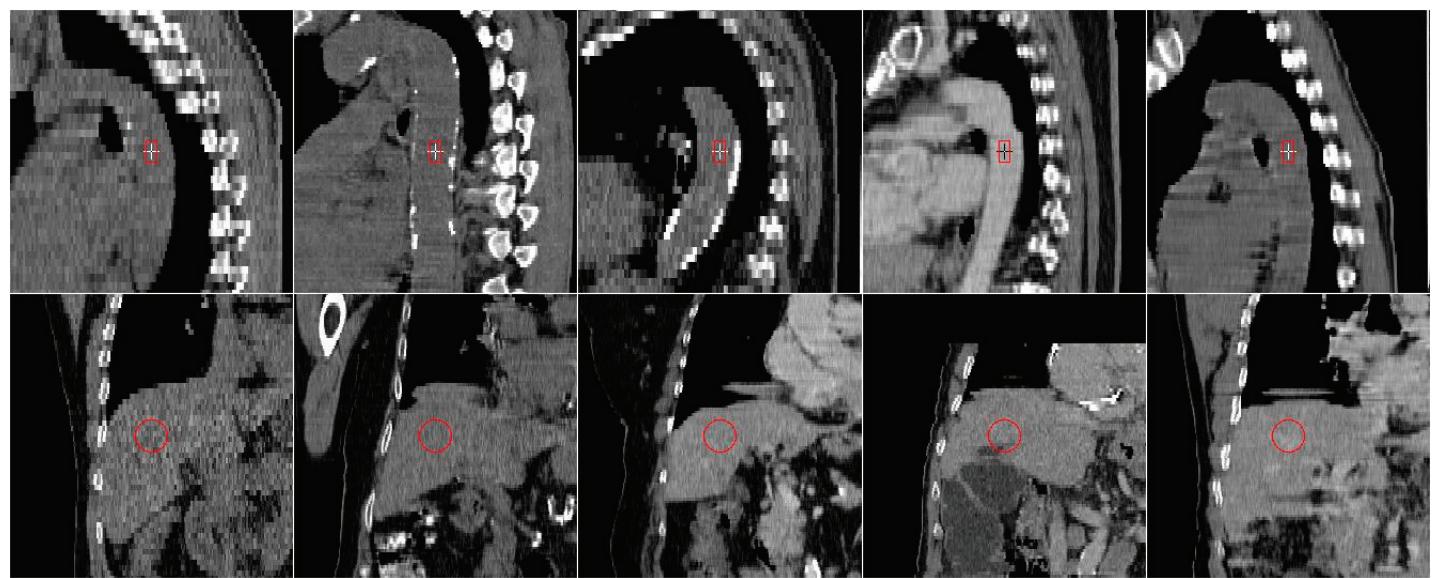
ALPHA can automatically align PET/CT with MR images based on shared anatomical landmarks.
